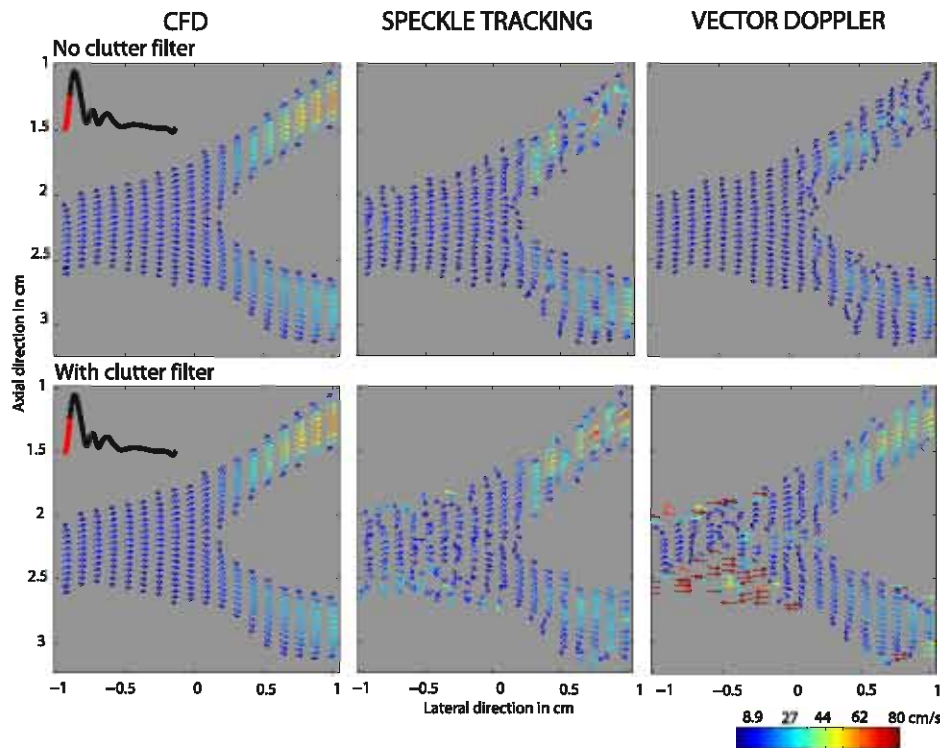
The effect of using a 5th order FIR clutter filter for both speckle tracking and vector Doppler velocity estimates, compared to the true flow situation. Results are shown for systolic acceleration and for the 4 kHz setup. For speckle tracking, a more chaotic flow picture is obtained due to clutter filtering, and a bias compared to the theoretical estimates is also noticeable. For vector Doppler, low flow zones are transformed into seemingly high flow zones because of the clutter filter.
